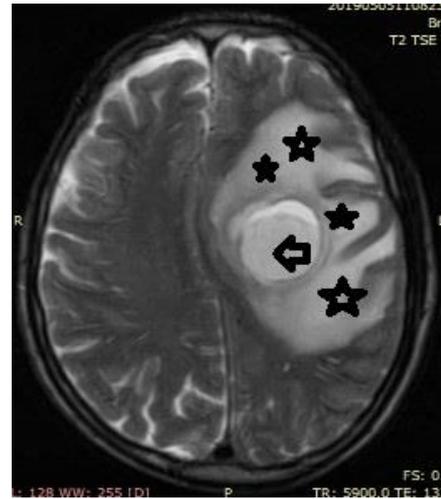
T2 TSE MRI showing a deep-seated intracerebral abscess (arrow) with extensive surrounding oedema (stars).
